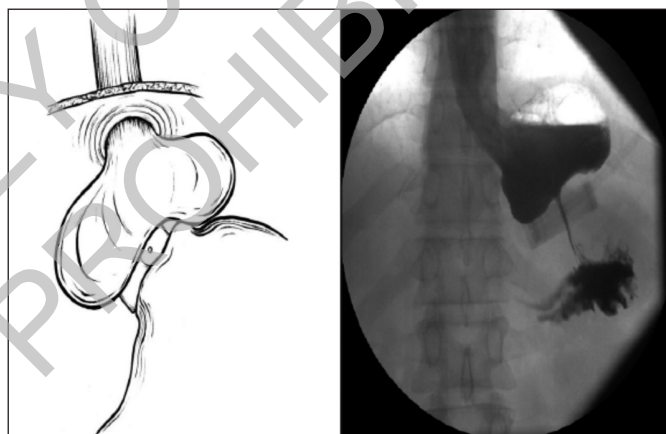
Type 3 slippage (symmetric dilation of the proximal gastric pouch from an overpressure inside the band). The band is in normal position; the pouch is symmetrically enlarged; x-ray shows pouch pooling of contrast above with poor emptying.
